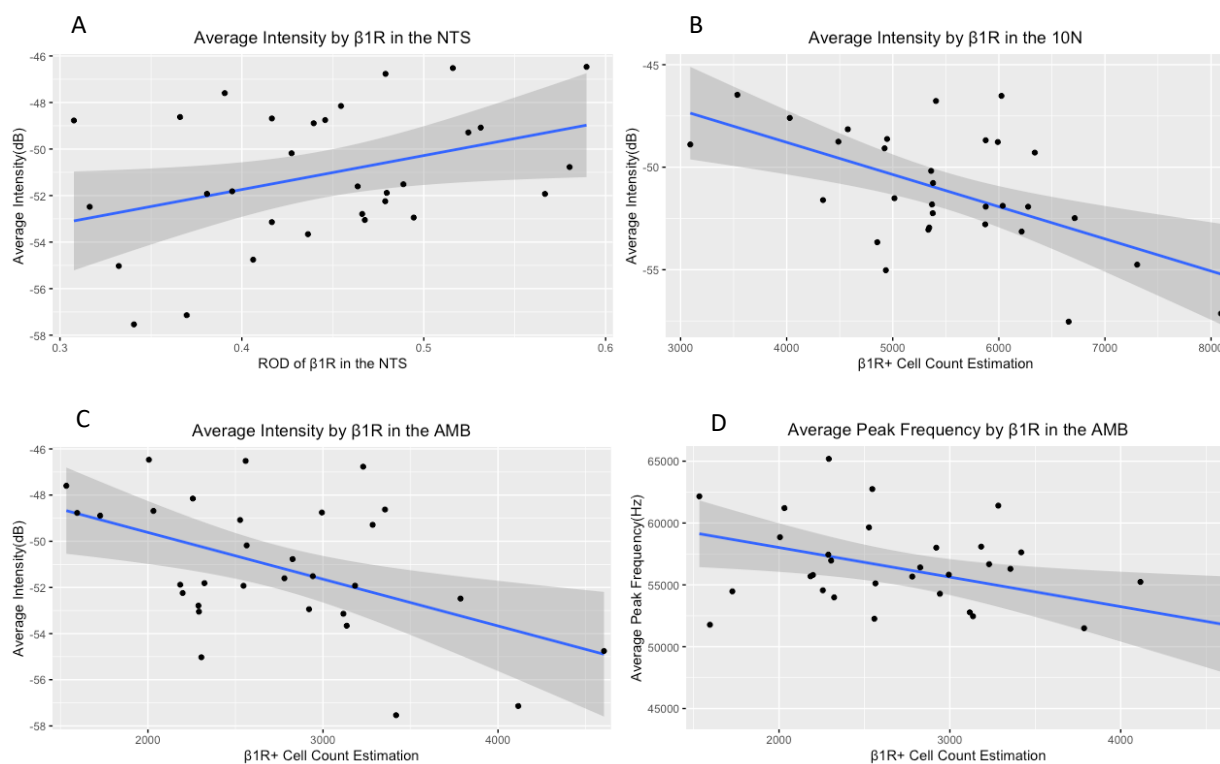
Relationships between $\beta 1R$ immunoreactivity and ultrasonic vocalization intensity and average peak frequency. A: Average intensity by ROD of $\beta 1R$ in the NTS. B: Average intensity by $\beta 1R+$ cell count estimates in the 10N C: Average intensity by $\beta 1R$ cell count estimates in the AMB. D: Average peak frequency by $\beta 1R$ cell count estimates in the AMB. Increases in cell count estimates in the AMB and 10N were associated with decreases in average intensity, and decreases in ROD in the NTS were associated with increases in intensity. Decreases in cell count estimation in the AMB were associated with decreases in Average peak Frequency. $\beta 1R$: $\beta 1$ adrenoreceptor immunoreactivity. 10N: dorsal motor nucleus of the vagus. AMB: nucleus ambiguus. NTS: Nucleus of the solitary tract. dB: decibels. Hz: Hertz. ROD: relative optical density. Gray shading indicates 95% confidence interval.
